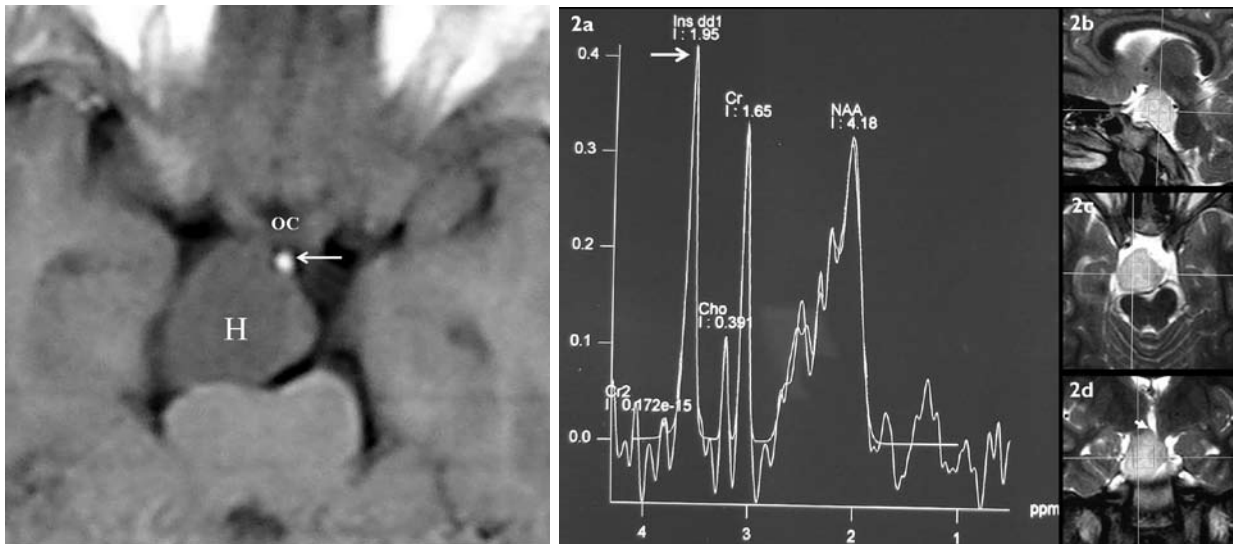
Axial contrast-enhanced T1-weighted MR image shows the hypothalamic hamartoma (H) in the supra-sellar area posterior to the pituitary stalk (arrow) and the optic chiasma (OC).
